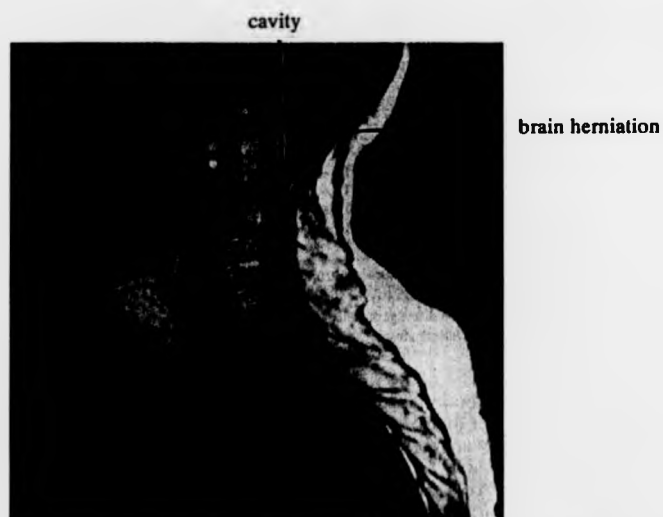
Magnetic resonance image demonstrating the appearance of a syrinx after craniocervical decompression. (Sgouros & Williams, 1995, p. 4)
